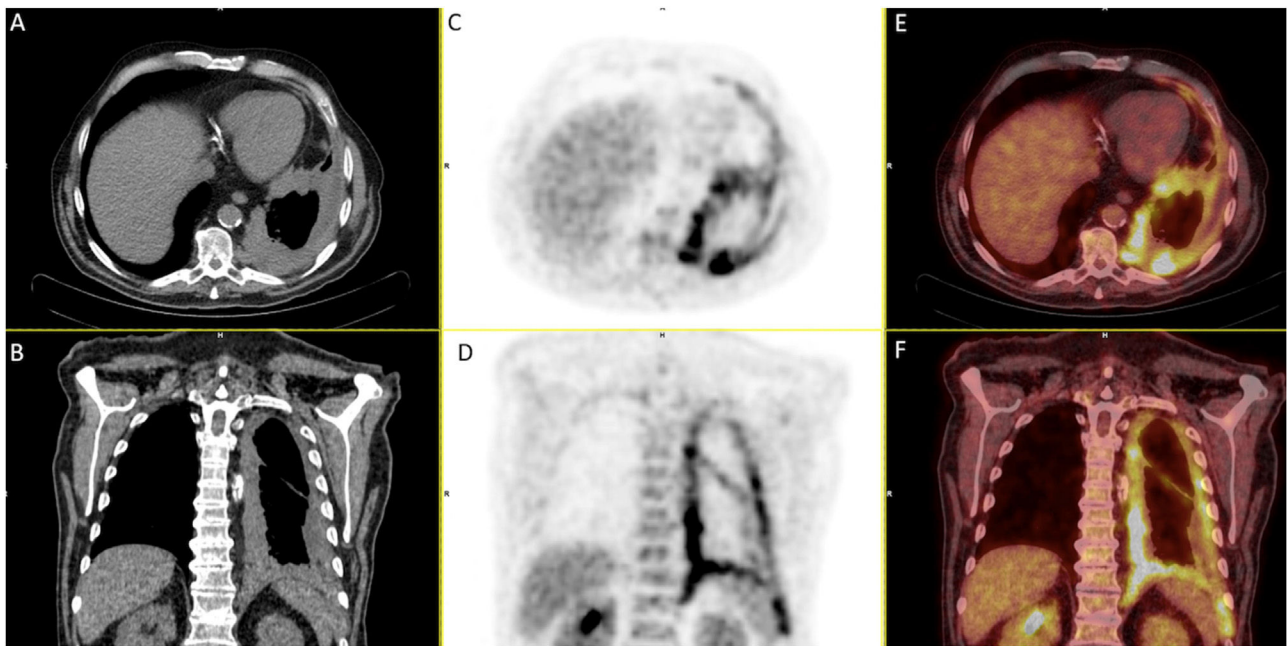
[¹⁸F]FDG PET/CT with left pleural effusion in the CT study (A and B). The [¹⁸F]FDG images (C and D) and the [¹⁸F]FDG PET/CT fusion images (E and F) present increased glycolytic metabolism with an encapsulation pattern. Pathological diagnosis: mesothelioma.
